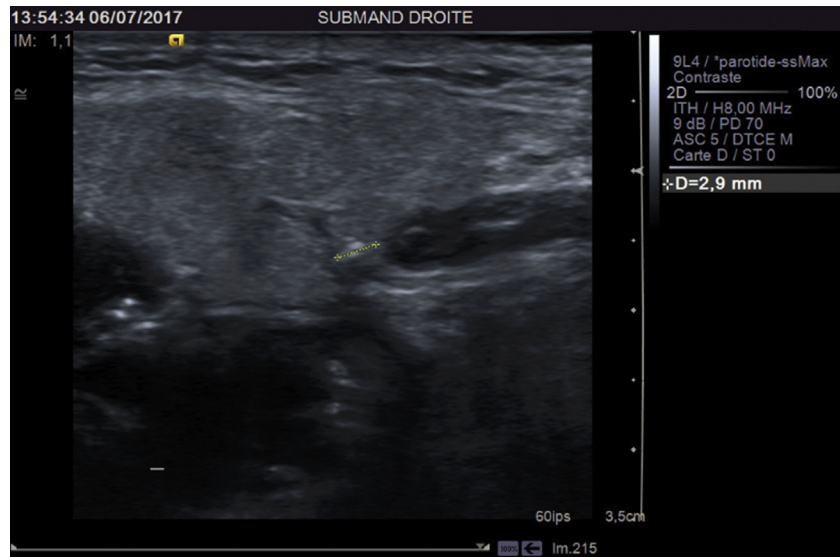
Ultrasound of stone in submandibular gland. (Courtesy of Philippe Katz, MD, Paris, France.)
